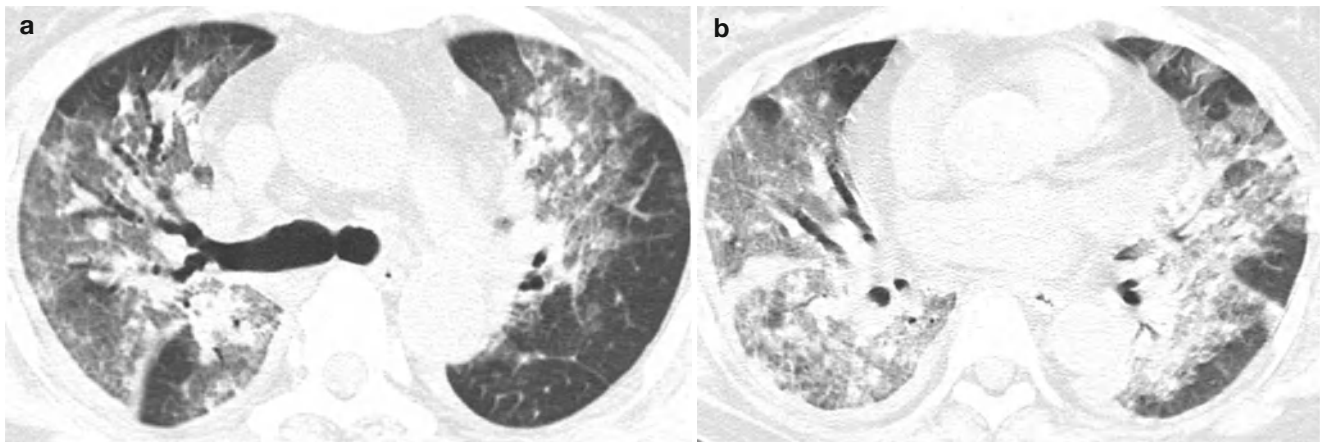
Influenza A (H1N1) pneumonia showing acute interstitial pneumonia pattern in a 58-year-old woman with multiple myeloma. (a, b) Lung window images of CT scan (2.5-mm section thickness) obtained at level of right upper lobar bronchus (a) and lower lobar bronchi (b), respectively, show patchy and extensive parenchymal opacity
